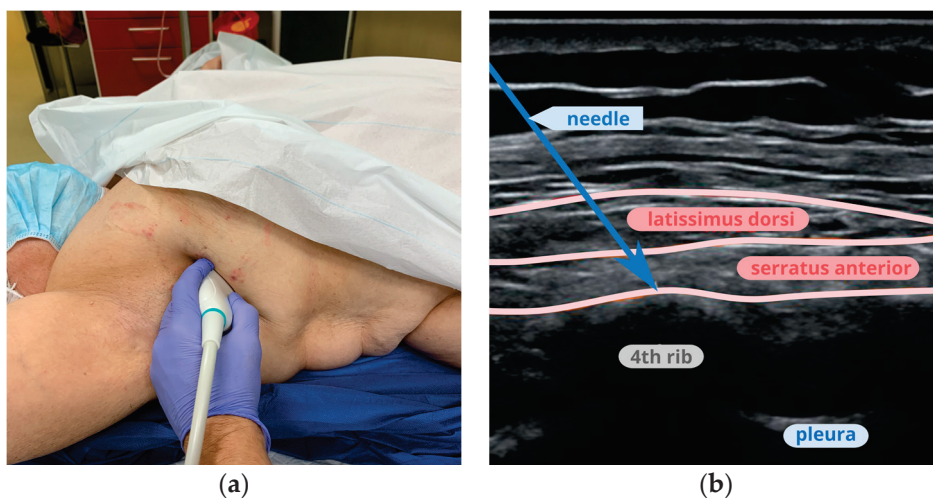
Serratus anterior plane block: (a) placement of the probe at the fourth-rib level for SAPB; (b) an ultrasound image of the serratus anterior and latissimus dorsi muscles.
